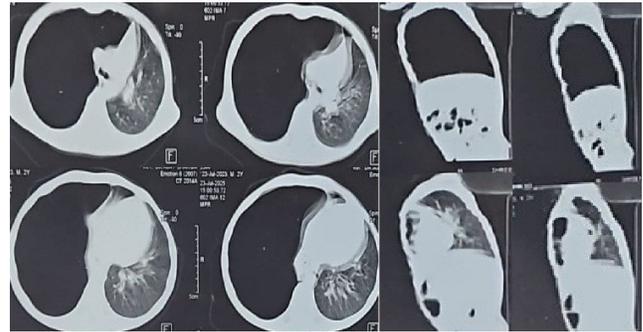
HRCT image suggesting a large right-sided pneumothorax causing severe compression on the left lung and trachea—mediastinal shift to the left
